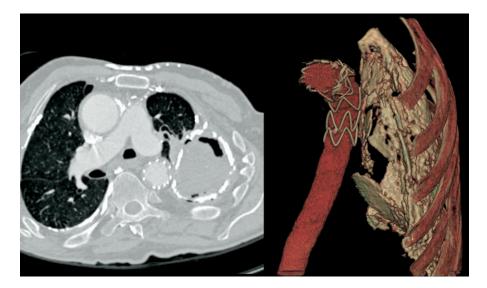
Postoperative computed tomography (CT) and CT-based three-dimensional reconstruction of the thorax with the endoprosthesis and the exclusion of the tuberculous aneurysm. Note the close anatomical contact between the endoprosthesis and the pulmonary cavitation.
